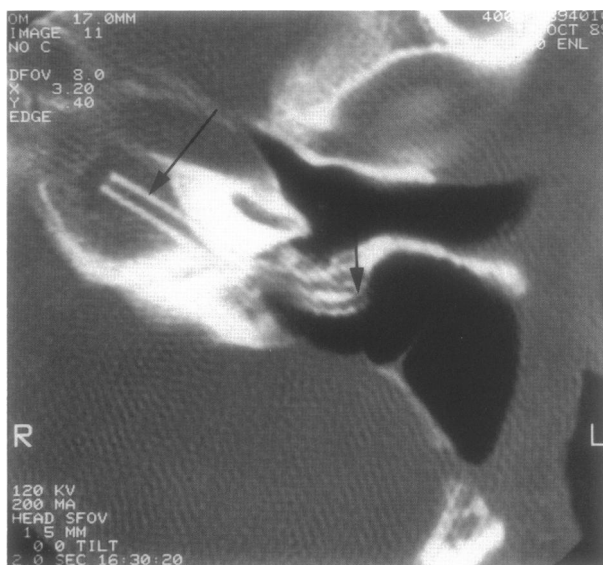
Postoperative high resolution computed tomography scan with tube extending from cyst to mastoid (arrows).
